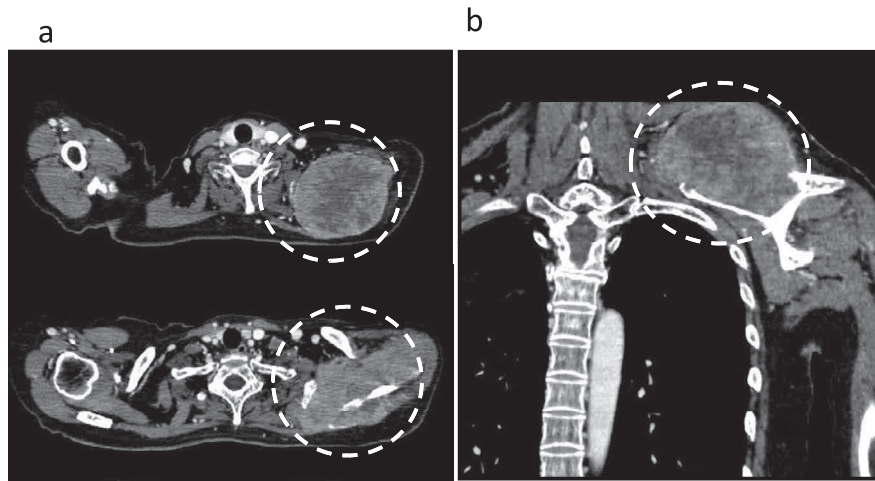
Case 5. A 47-year-old woman with a metastatic tumor of the left shoulder (uterine leiomyosarcoma). Tumor size was $13 \times 10 \times 10$ cm ; a : enhanced CT, b : MPR coronal view.
